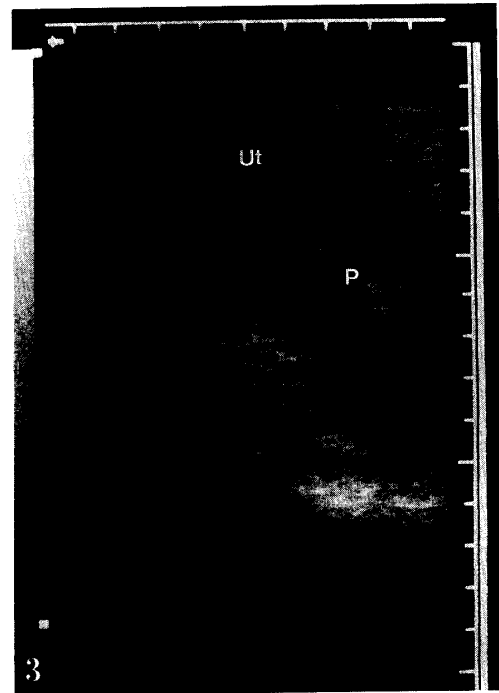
Longitudinal view Ultrasonogram of retention of placenta (P). Ut; uterus.
